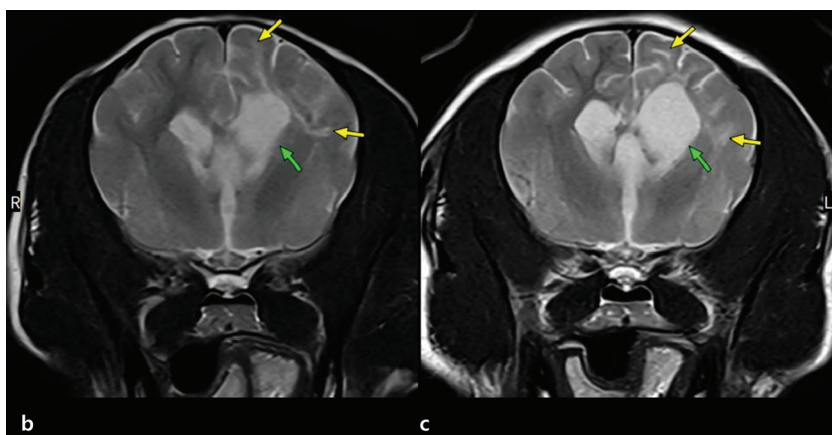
Serial T2-weighted MR images of the left parietal and temporal lobes
